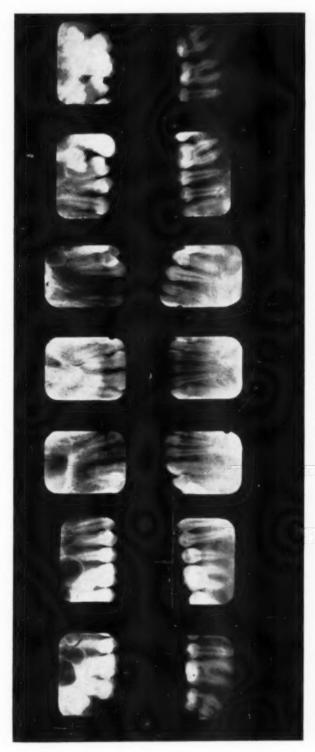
The full set of x-rays.
